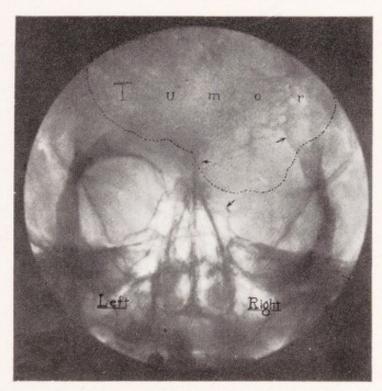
Case 18. Anteroposterior X-ray, showing destruction of roof of orbit and supraorbital ridge by tumor.
